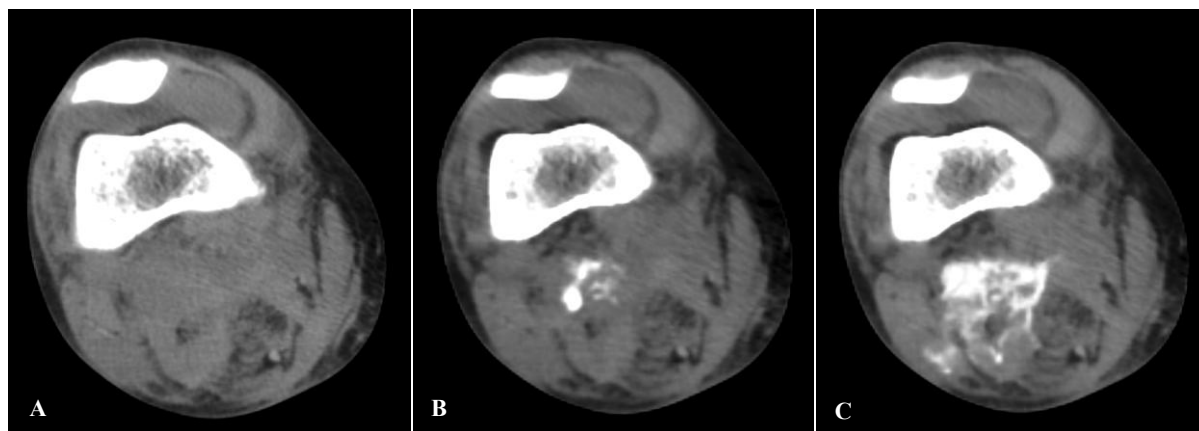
(A-C): Contrast-enhanced CT of the right leg, right above the knee joint, with images before (left), after endovenous contrast in arterial phase (middle) and in venous phase (right) that show in the location of the popliteal artery a contrast blush in the arterial phase that increases in size in the venous phase, consistent with hemorrhage with origin in a popliteal artery rupture.
